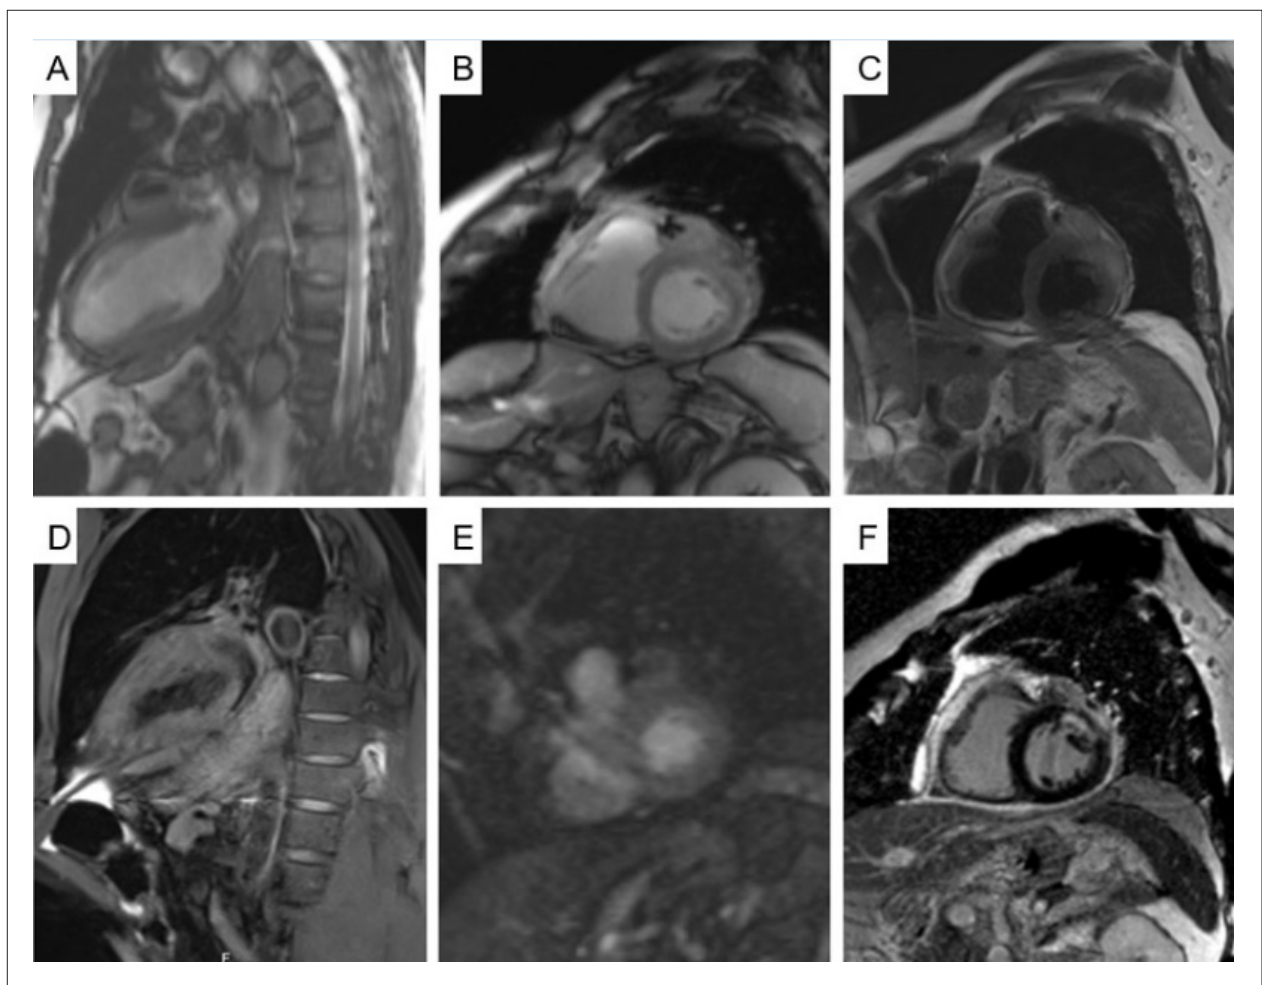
cMRI (A) (B) b-SSFP cine images revealing an elongated mass (measuring 25 x 13 x 40 mm) adjacent to the basal anterior and antero-lateral segments and in close contact with the LAD artery stent. (C) High intensity signal on T2-weighted images. (D) Isointense signal intensity on T1-weighted images. (E) First pass perfusion of the mass. (F) LGE with heterogeneous appearance of the mass and diffuse contrast-enhanced pericardium.
